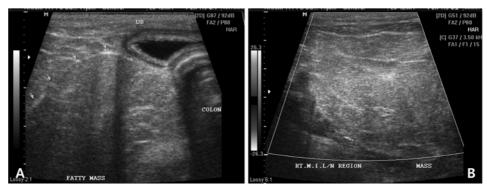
The mass shows uniformly hyperechoic with a coarse internal echo texture and has outer hyperechoic capsule (arrows) on the abdominal ultrasonography (A). On the color Doppler examination, the mass appears almost absent of blood flow signal (B).
